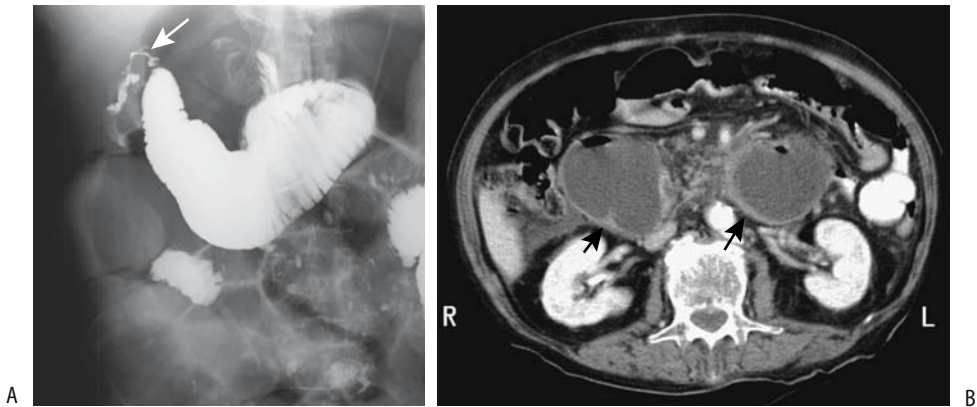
A: Blown afferent loop stump (arrow) after a Billroth II resection. The afferent loop is obstructed. B: Another patient with an obstructed afferent loop after a Billroth II resection. Contrast-enhanced CT reveals a dilated, fluid-filled small bowel loop having an enhancing wall (arrows). (Courtesy of Patrick Fultz, M.D., University of Rochester.)
